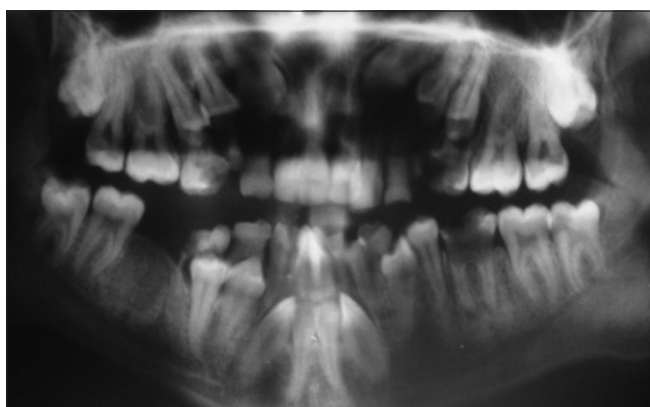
Radiograph showing retained permanent teeth
